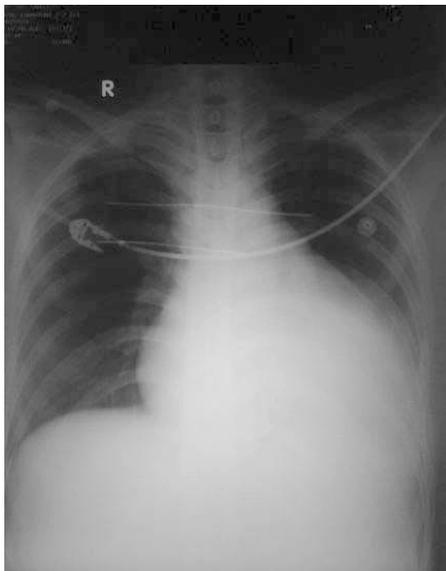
Chest X-ray showed enlargement of the cardiac chambers
